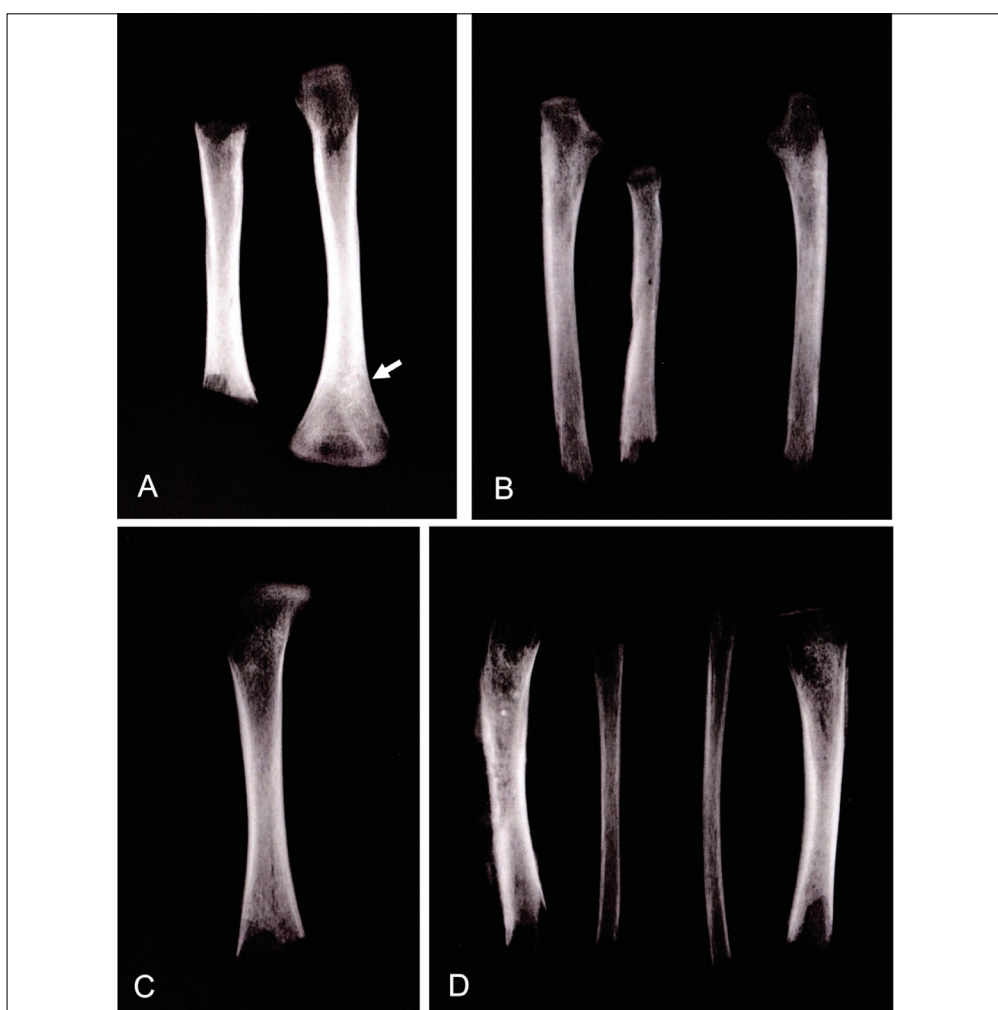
Conventional radiography of the long bones. A) Humeri with Harris Lines (white arrow). B) Forearm bones. C) Right femur. D) Tibiae and fibulae.
